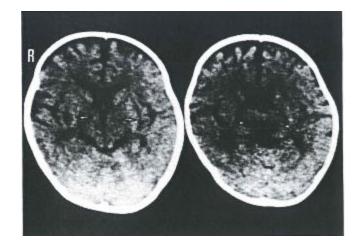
In the initial CT scans taken on October 4 when the patient was admitted to the hospital, faint areas of low density can be seen in both the thalami (indicated by arrowheads) and the putamen (marked by arrows) on both sides of the brain.
